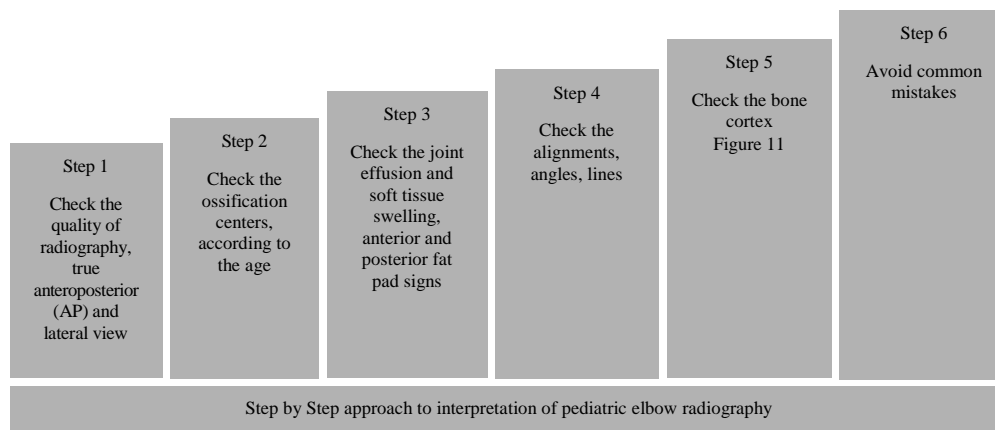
A stepwise approach to pediatric elbow x-ray radiography
